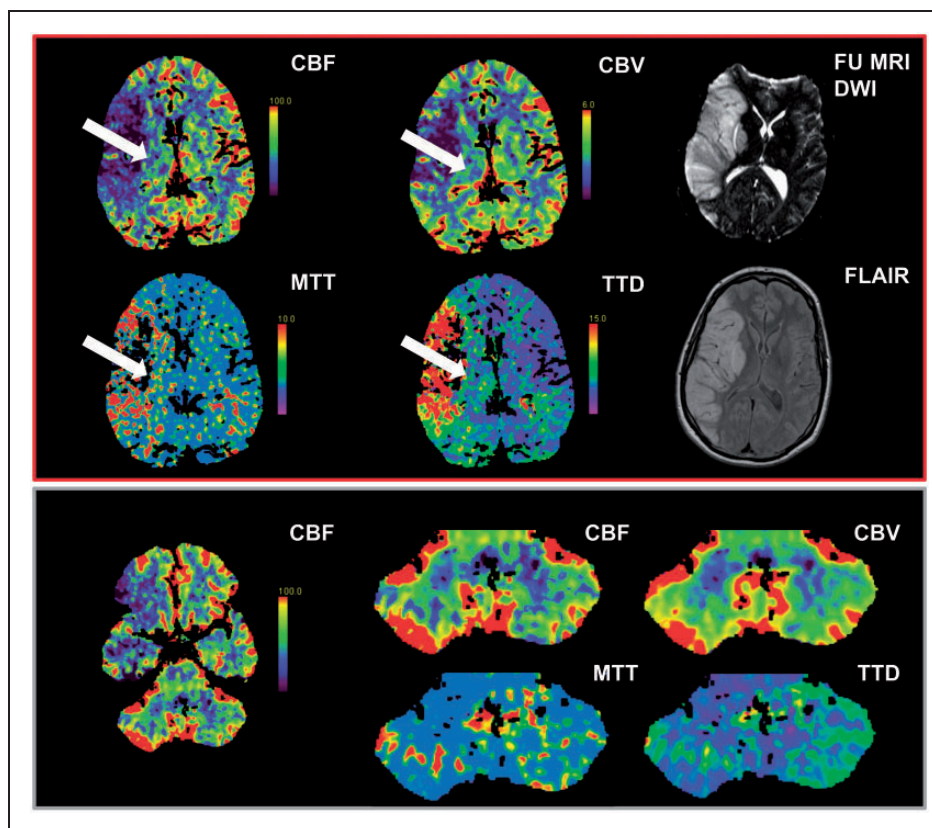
A representative case of MCA infarction, ipsilateral thalamic hypoperfusion and CCD is shown in Figure 3. CTP maps (CBF, CBV, MTT and TTD) of the supratentorial perfusion including the thalamus as well as the respective follow-up MRI (DWI and FLAIR) are shown in the red frame. White arrows indicate the area of thalamic hypoperfusion. The cerebellar hypoperfusion (left side: CBF, right side: higher resolution CBF, CBV, MTT and TTD) are shown in the gray frame. Images were obtained from a 48 year-old male with acute left-sided hemiparesis due to a right-sided MI-occlusion. Time from symptom onset to CTP imaging was 190 min and to MRI follow-up 64 h, respectively. After CT-workup, rtPA was administered immediately and subsequent (successful) mechanical recanalisation of the MI-segment was performed.
